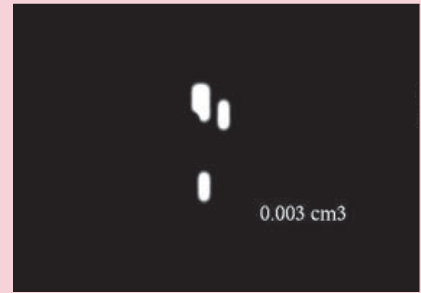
CT image of the filling material shown in Fig. 4 after application of the "threshold" tool in the mesiolingual canal. Calculation of the remaining volume of filling material is shown.
